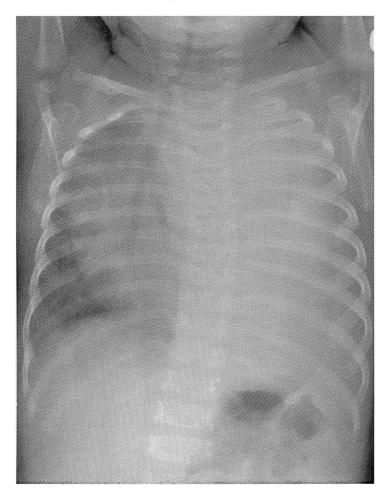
Chest radiograph of a large thoracic neuroblastoma in a 9-month-old girl with tracheal compression.
